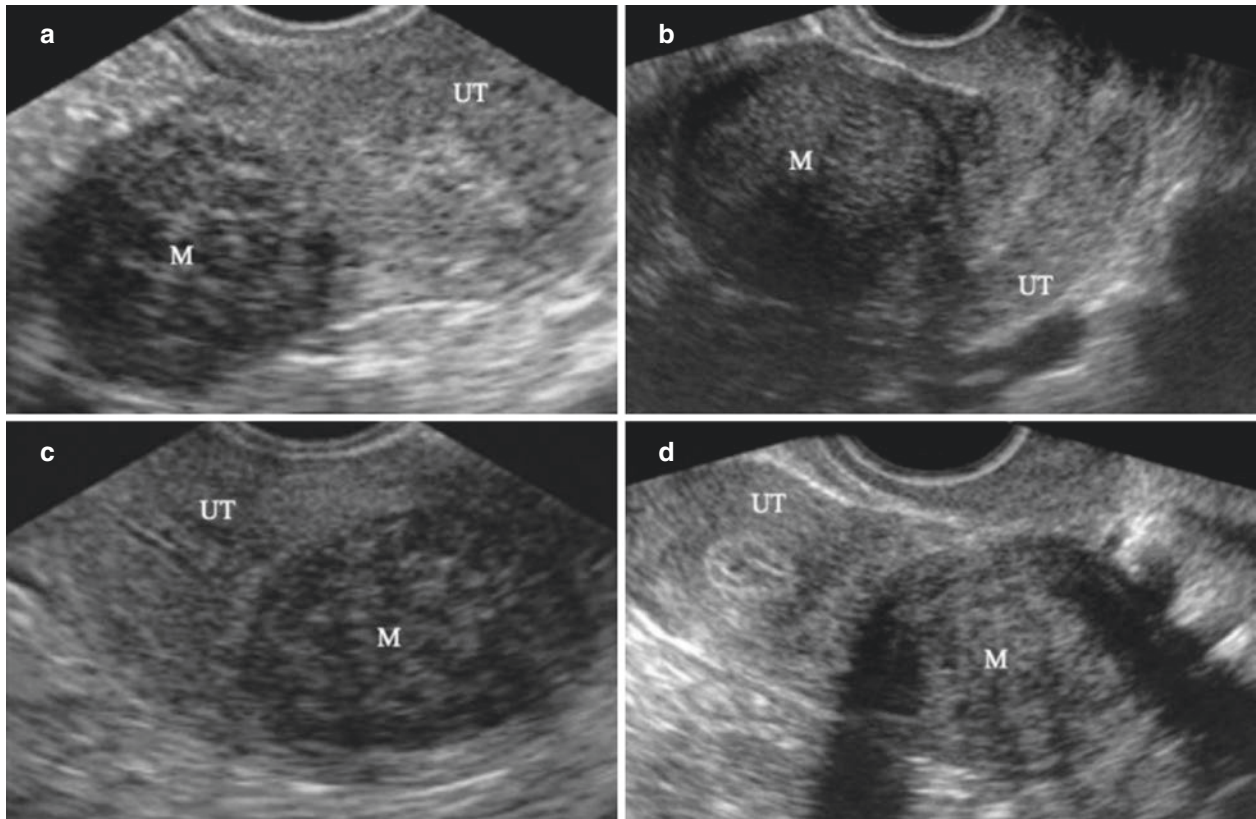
Leiomyoma (IV). (a-c) Hypoechoic leiomyomas shown by sonogram. (d) Leiomyoma with bilateral attenuation
